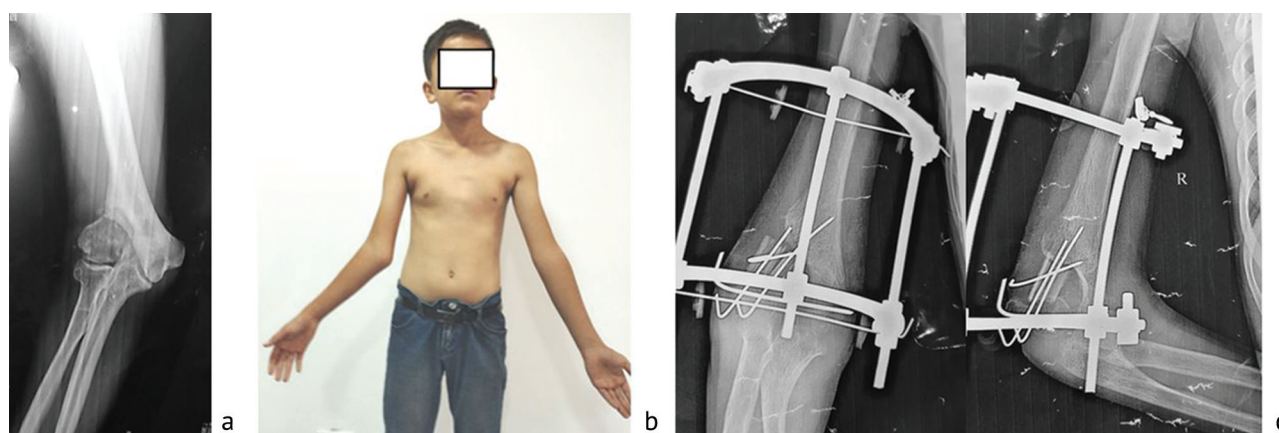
A 13-year-old patient N.Sh. diagnosed with nonunion of the LHC with a history of 9 years: (a) radiograph of the elbow joint; (b) preoperative photo of the patient; (c, d) postoperative radiographs; (d) realigned axis of the arm, joint function
